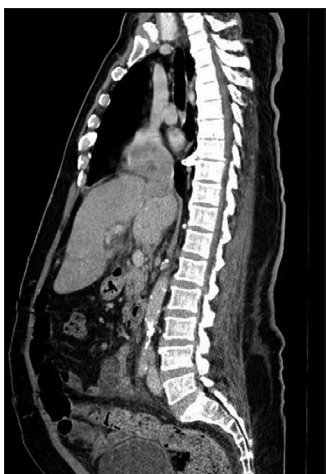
This is a sagittal plane of Computed tomography scan abdomen that showed hepatoma at segments 6 and 7 invading the right hepatic vein as well as confluence of the inferior vena cava extending into the right atrium of the heart with small ascites with no splenomegaly or other metastasis
